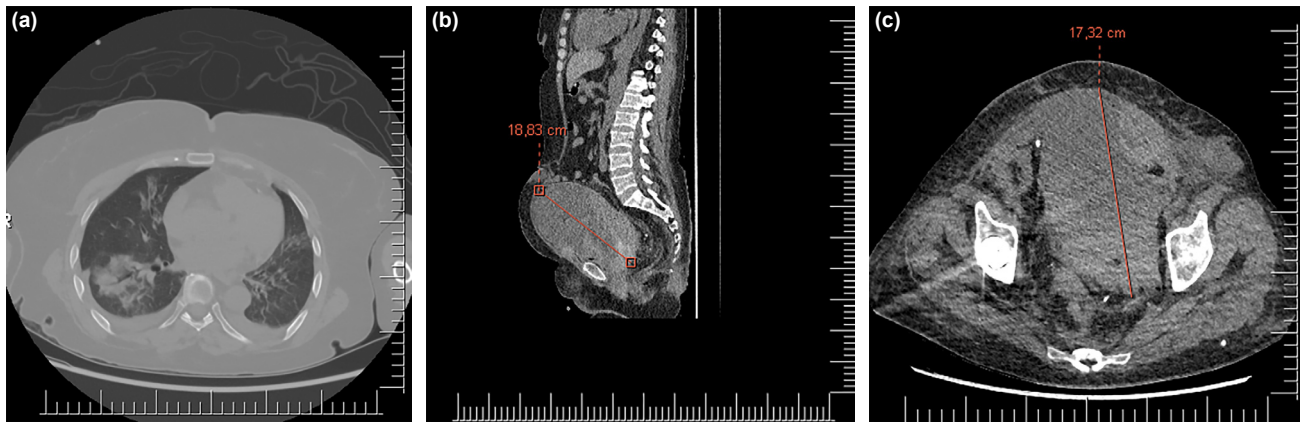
Case 3 - (a) Thorax BT and viral pneumonia compatible with COVID-19, (b) abdominopelvic computed tomography (CT), sagittal image, and left rectus sheath hematomas (RSH), and (c) abdominopelvic CT, axial image, and left RSH ruptured into the abdominopelvic cavity.
